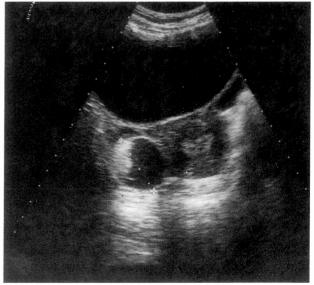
Case 1*. Pelvic ultrasonography showing a right ovarian cyst with calcifications.
